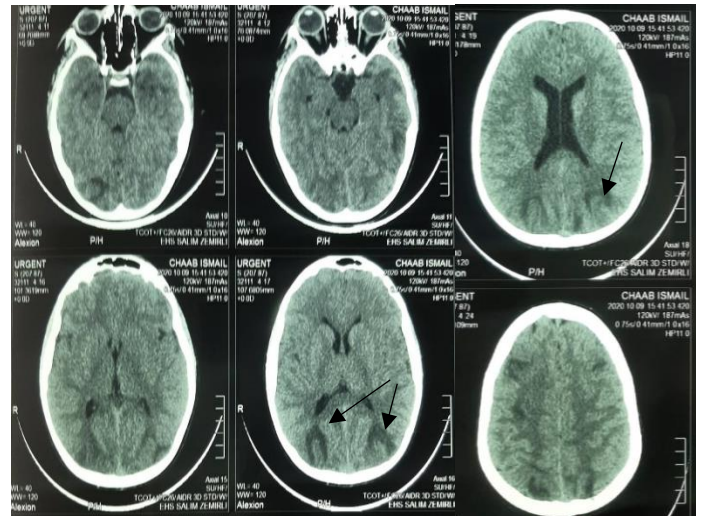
Occipital hypodense lesion, cortico-subcortical bilateral asymmetric in CT scan.
